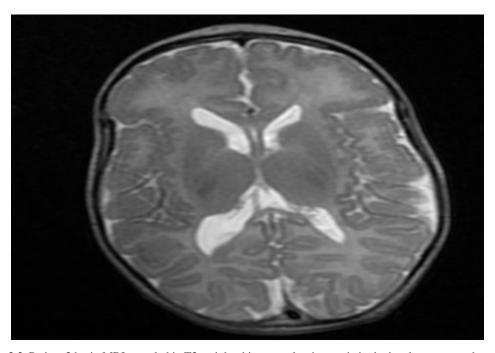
Patient 2 brain MRI revealed in T2 weighted image polymicrogyria in the insular cortex and temporal lobe.
